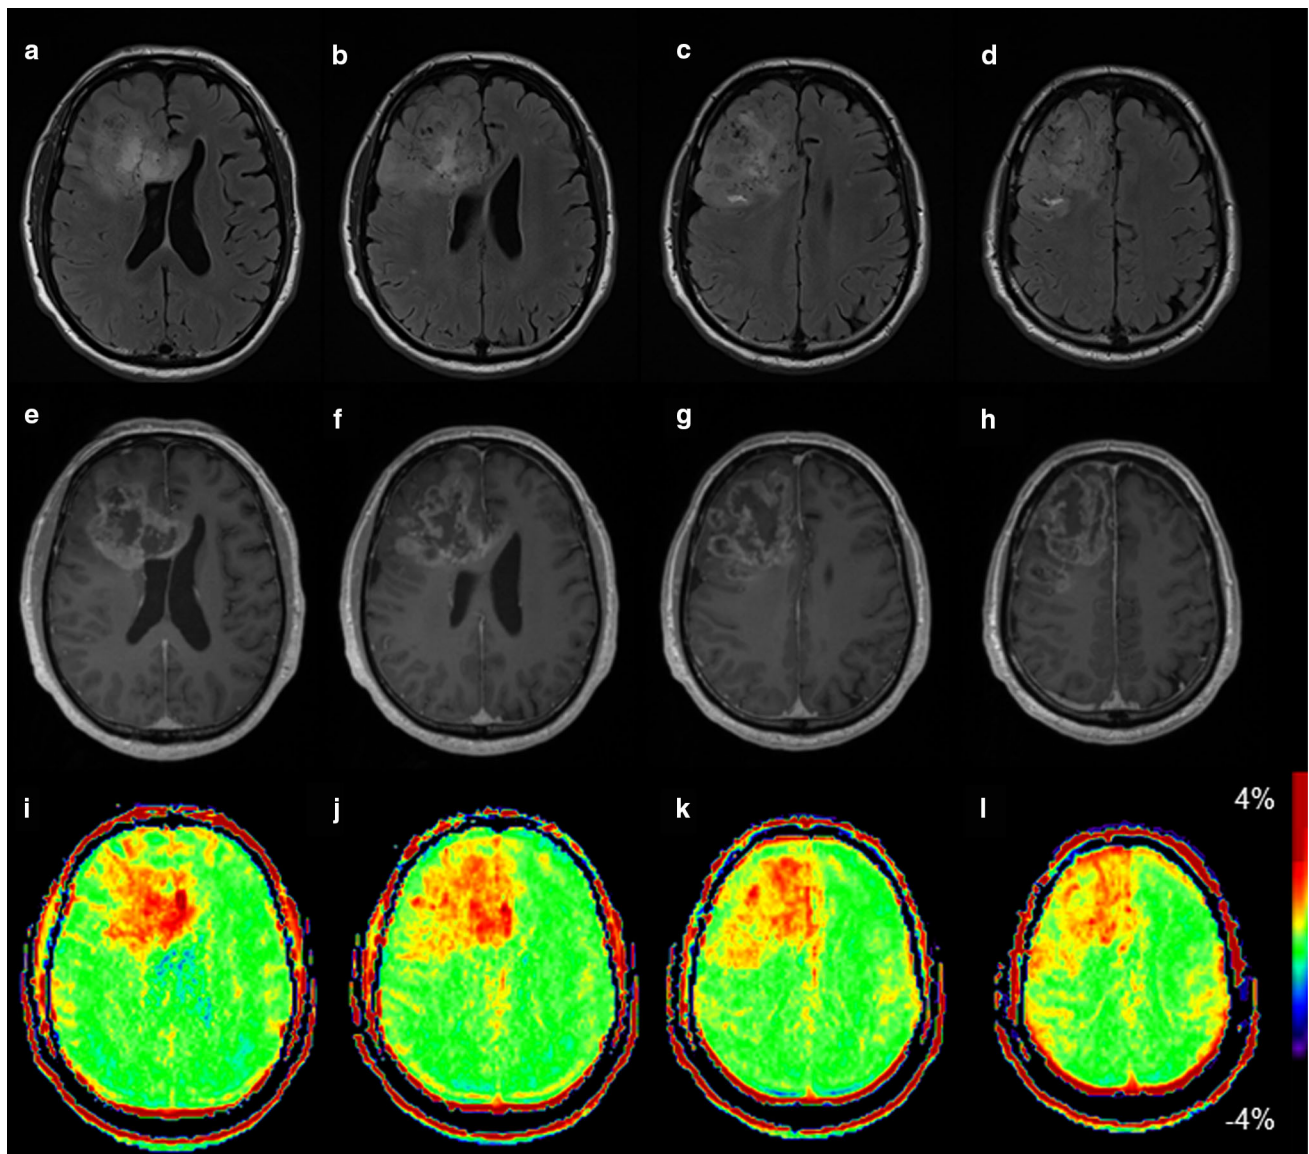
Slice differences in APTasym imaging of a 77-year-old man with glioblastoma. FLAIR images a–d show a large tumor mainly located in the *right frontal lobe*. Contrast-enhanced T1-weighted
